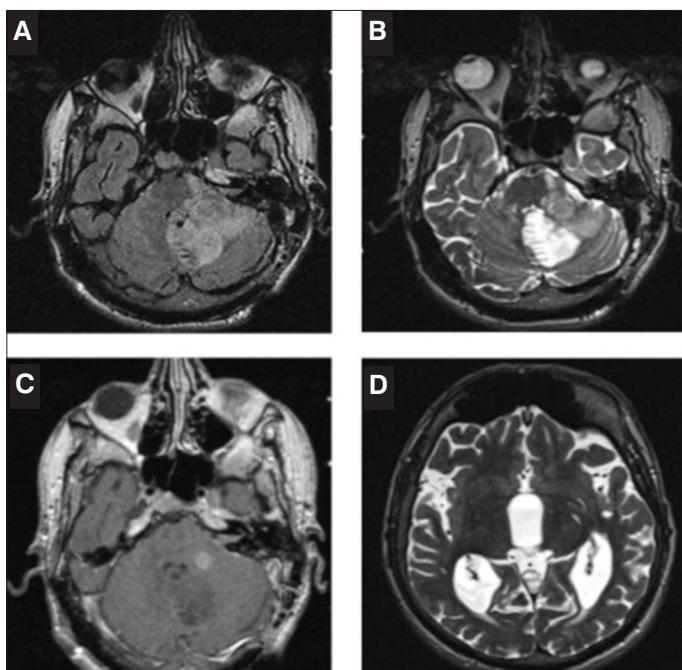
Slightly enhanced tumor after contrast medium injection with multiple cystic components on T1 weighted images (1A). A strong signal was observed on T2 weighted images (1B). A slightly hyperintense signal was observed on FLAIR weighted images (1C). Obstructive hydrocephalus was observed with enlarged lateral, third and fourth ventricles (1D).
